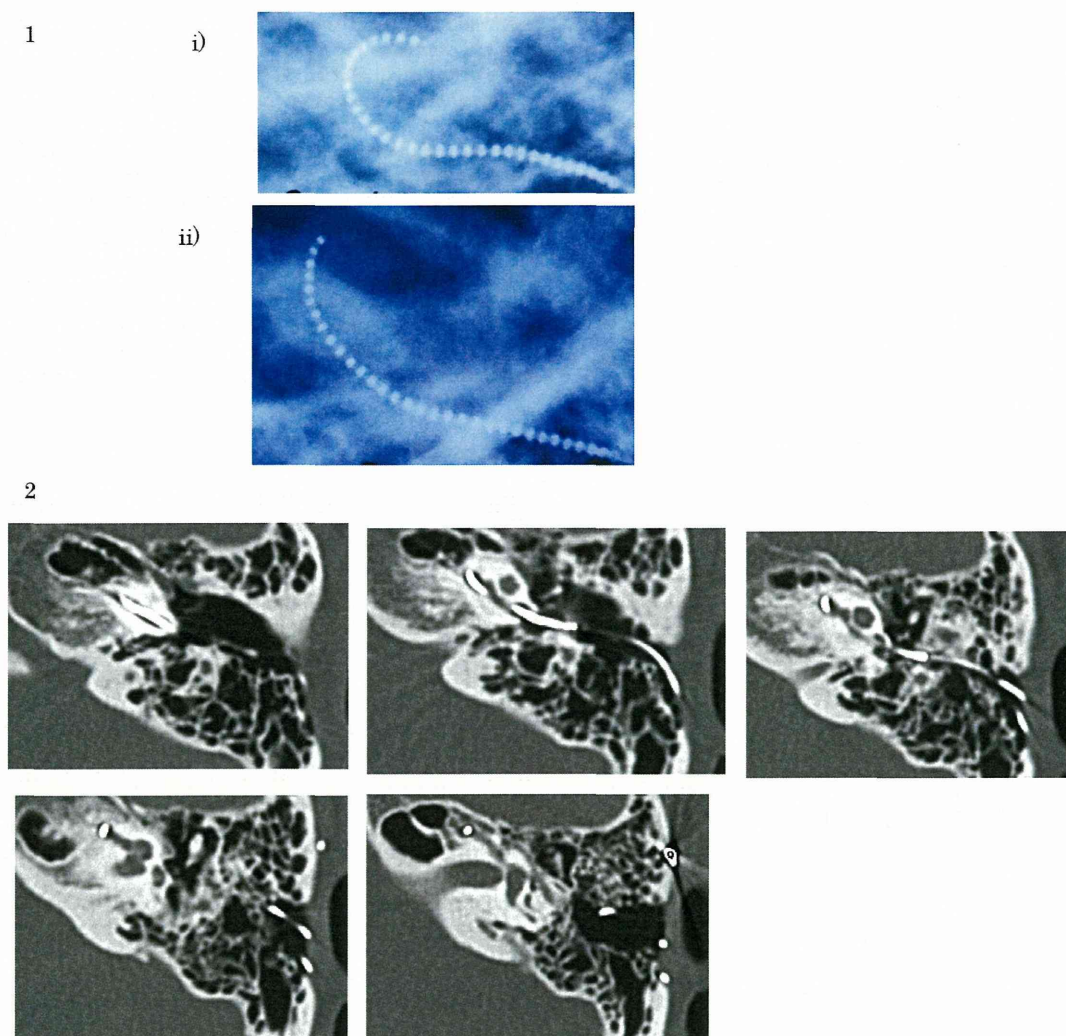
(1) X-ray images of the electrode. At 4 years postoperatively, the electrode is confirmed to be in the cochlea. At 8 years postoperatively, the tip of the electrode had shifted. (2) Computed tomographic images of the electrode show osseous change in the cochlea and electrode extrusion.
